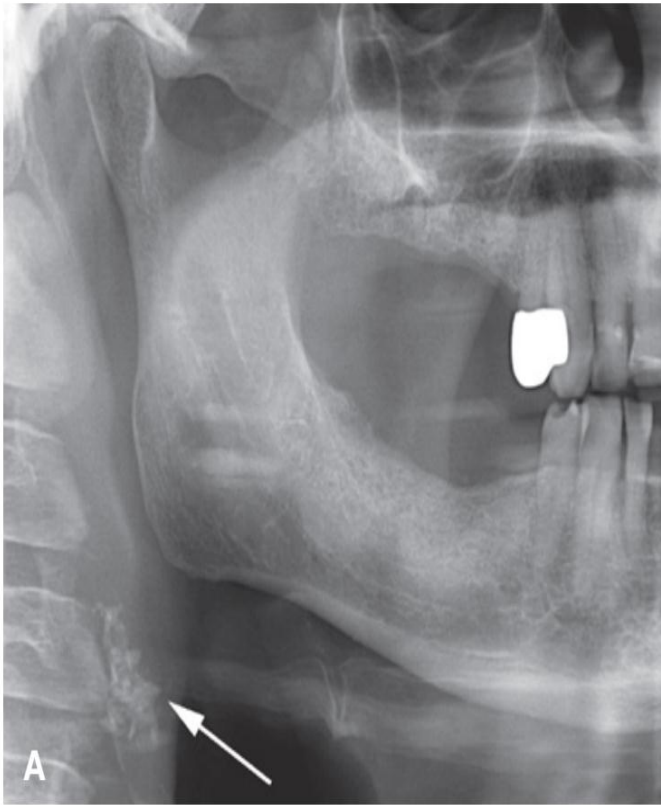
(A) Panoramic radiograph of a human skull. (B) Anteroposterior radiograph of a human skull.
